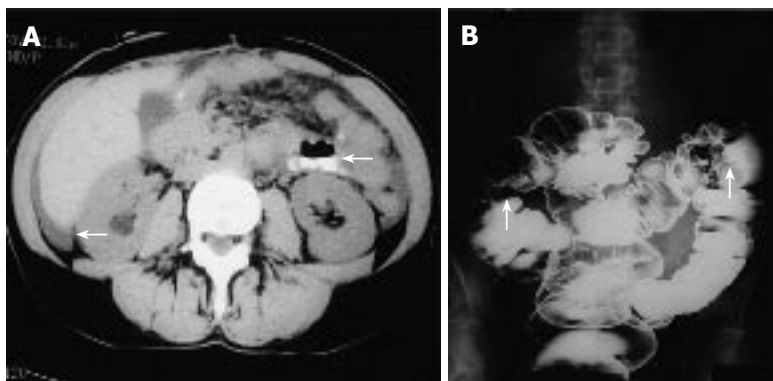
CT demonstrating a dilated loop of small bowel (arrow) and ascites (A), double-contrast barium enema demonstrating fixed eccentric strictures of the ascending colon and splenic flexure (arrows) with a third obscuring lesion seen within the sigmoid colon but not projected in profile on this image (B).
